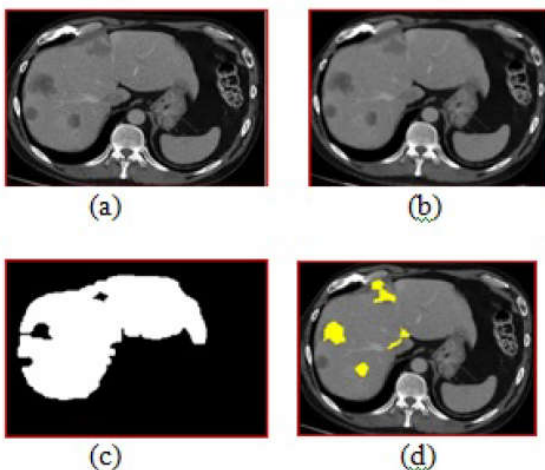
(a) Liver CT image; (b) Preprocessed image; (c) Feature Extracted image; (d) Tumor regions segmented image
